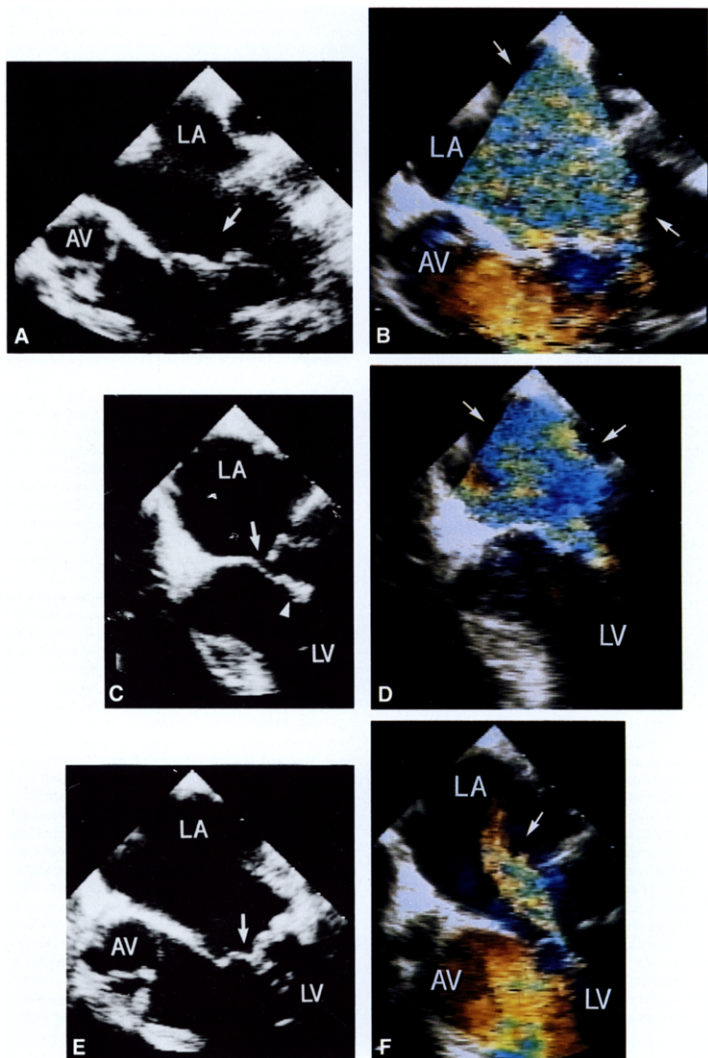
(opposite page). Intraoperative transesophageal echocardiography of bileaflet repair for mitral valve prolapse. A, Before mitral valve repair, bileaflet mitral valve prolapse is present (arrow) without flail leaflet segment. B, Severe central mitral regurgitation (arrows) is demonstrated by Doppler color flow mapping. C, After initial mitral valve repair, excessive plication of the anterior leaflet (arrowhead) results in override of the plicated posterior leaflet and malcoaptation (arrow) of the leaflets. D, Significant residual mitral regurgitation (arrows) is shown by Doppler color flow mapping, with an anteromedial trajectory with left atrial wraparound. E, After revised mitral valve repair, revision of the anterior leaflet plication now allows intact coaptation (arrow). F, Mild central mitral regurgitation is detected by Doppler color flow mapping (arrows). AV = aortic valve; LA = left atrium; LV = left ventricle.
